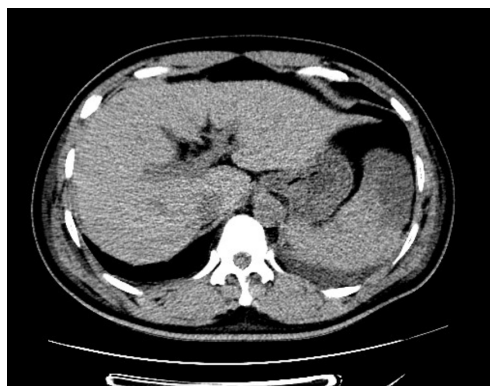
Splenic hematoma on chest CT.
